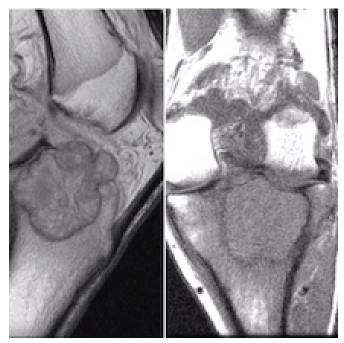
T1 weighted magnetic resonance imaging, saggital and coronal views showing intermediate signal intensity of the tumour.
